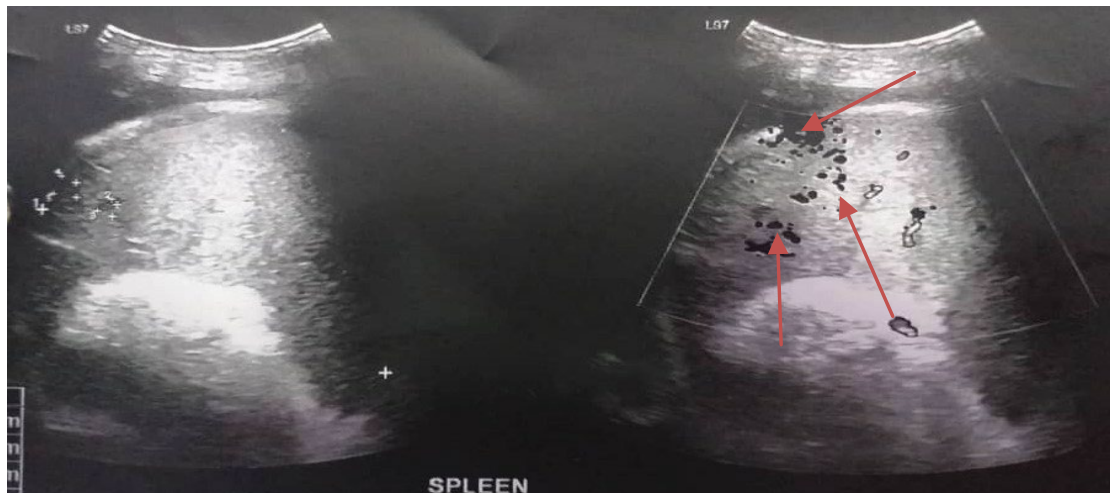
Abdominal ultrasound showed splenic microabscess.
